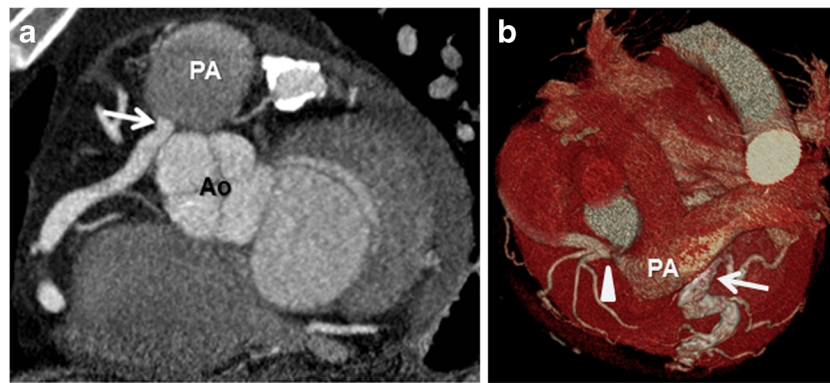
A 52-year-old male presents with dyspnea on exertion. An evaluation led to a coronary CTA. a The maximum intensity projection image demonstrates the anomalous right coronary artery arising directly from the pulmonary artery (ARCAPA) (*arrow*). b The three-dimensional
